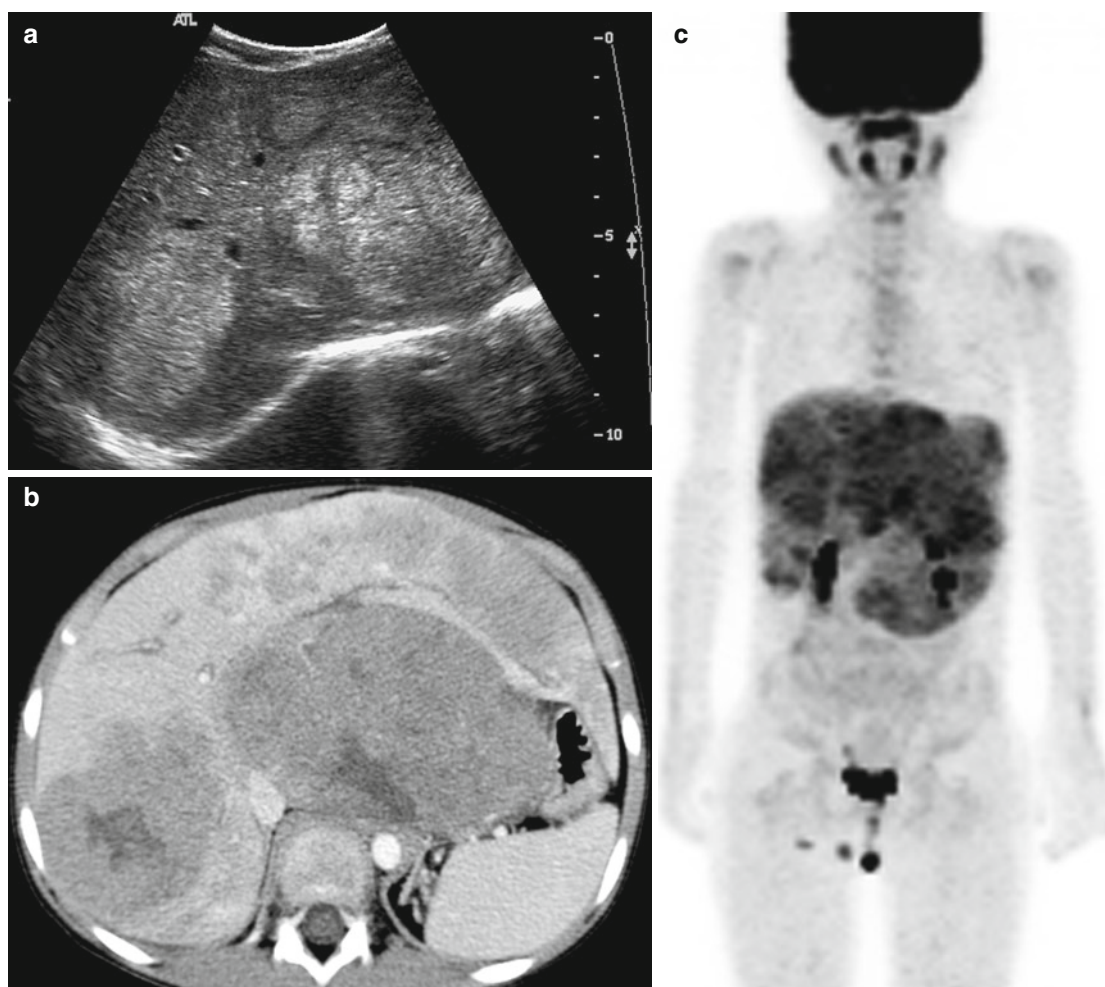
Multiple hepatoblastomas in a 4-year-old girl. (a) Abdominal US shows multiple heterogeneously hyperechoic masses in liver. (b) Contrast-enhanced abdominal CT also shows multiple masses with some central necrosis in both lobes of liver. (c) 18F-fludeoxyglucose
